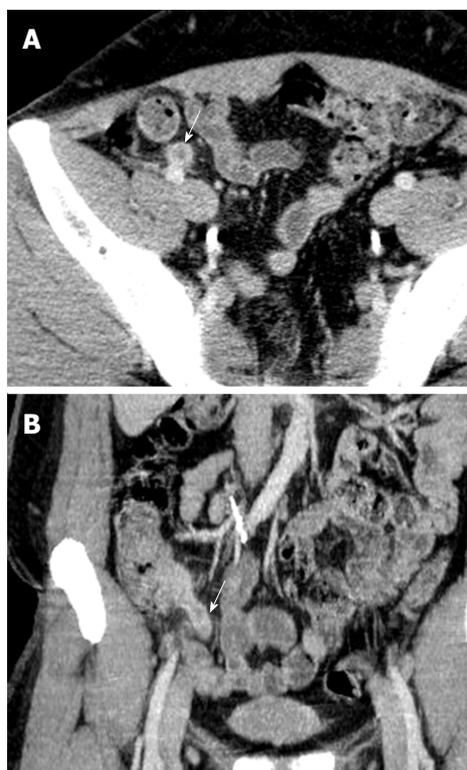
Appendiceal wall thickening. A: Cross-sectional (arrow); B: Coronal abdominal computed tomography scans showing appendiceal wall thickening suggestive of acute appendicitis (arrow).
